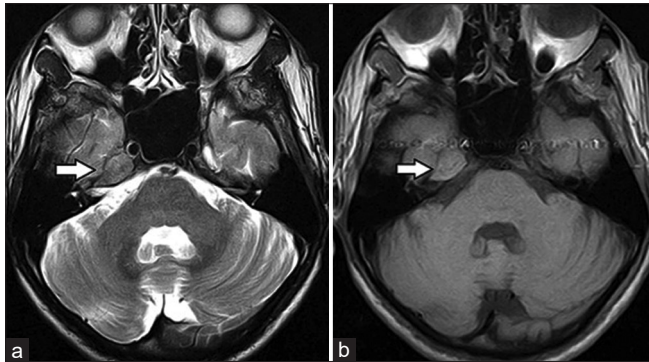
T2-weighted (a) and T1-weighted (b) axial magnetic resonance images. An extra-axial lesion involving the right petrous apex, extending along the Meckel's cave, indenting the temporal lobe and reaching along the posterior aspect of right cavernous sinus (arrows).
